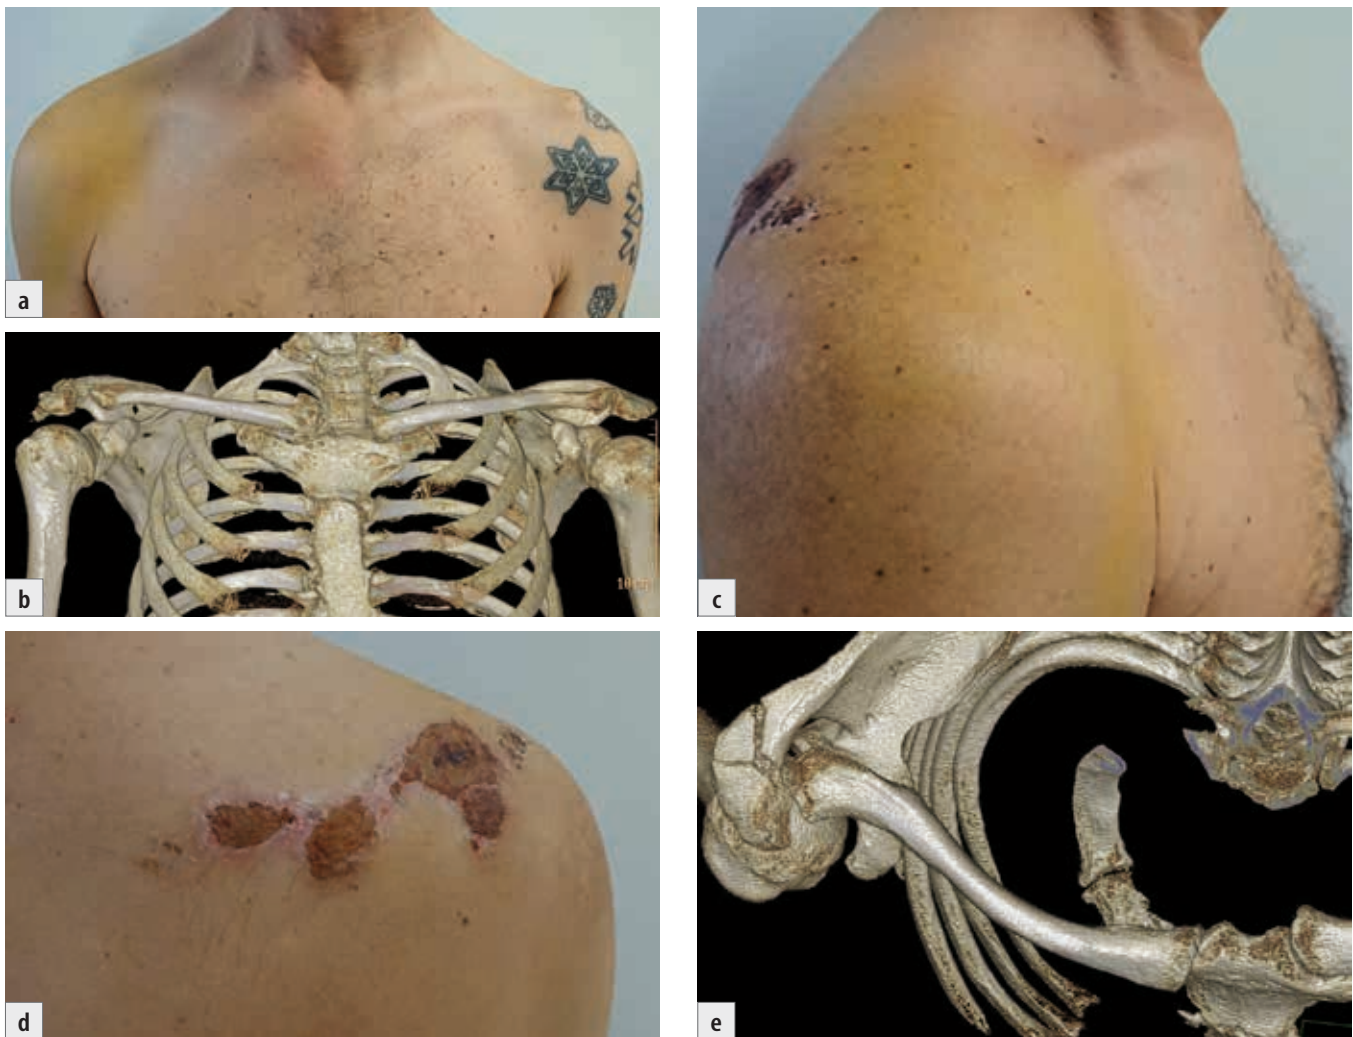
Patient with a fracture of the acromion and anterior subluxation in the SC joint: a) a visible swelling in the region of the SC joint and a resorbing hematoma in the region of the shoulder; b) 3D CT reconstruction; c) lateral view, abrasions in the region of the scapular spine and hematoma in the region of the shoulder; d) posterior view, abrasions in the region of the scapular spine; e) 3D CT reconstruction, a superior view showing subluxation of the SC joint, subluxation of the AC joint and fracture of the acromial angle.
